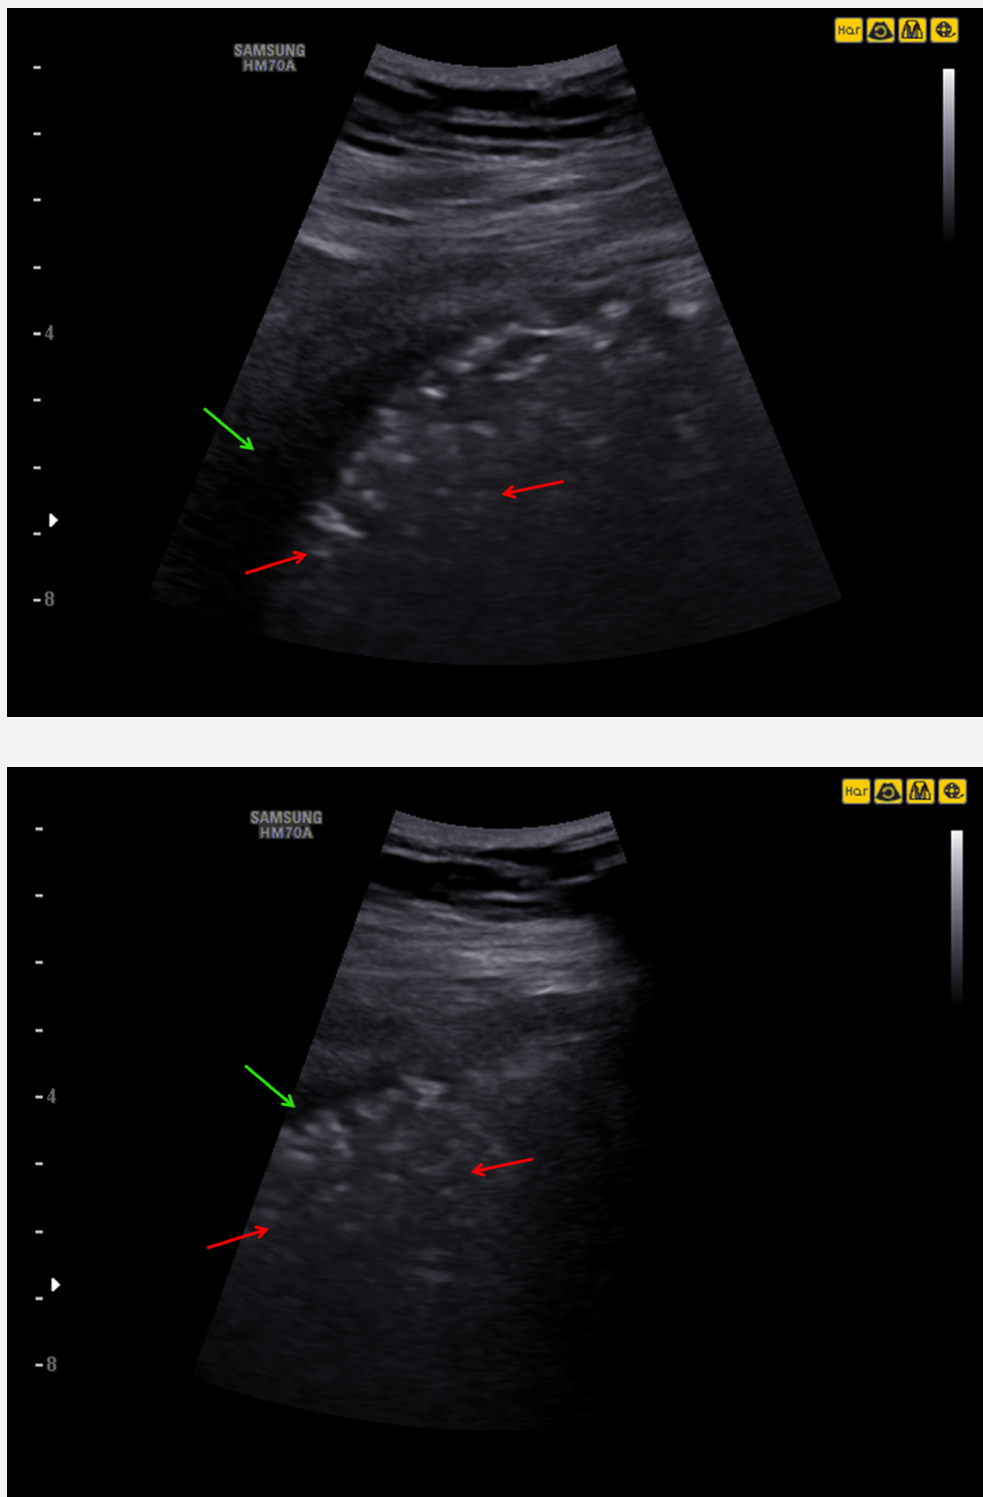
Lung ultrasound using the Samsung HM70A with a curved array transducer.
